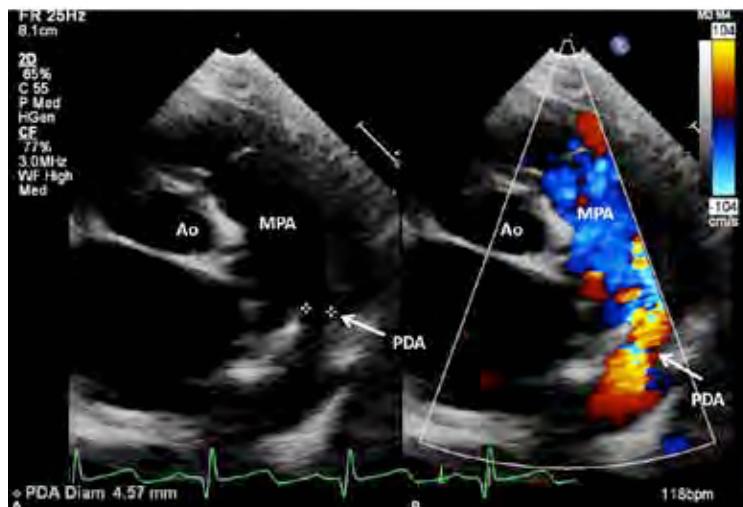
Selected video frames from precordial short axis views demonstrating a patent ductus arteriosus (PDA); 2D measurement of the minimal ductal diameter (A) with left to right shunt by color Doppler (B) are shown. AO, aorta; MPA, main pulmonary artery.
